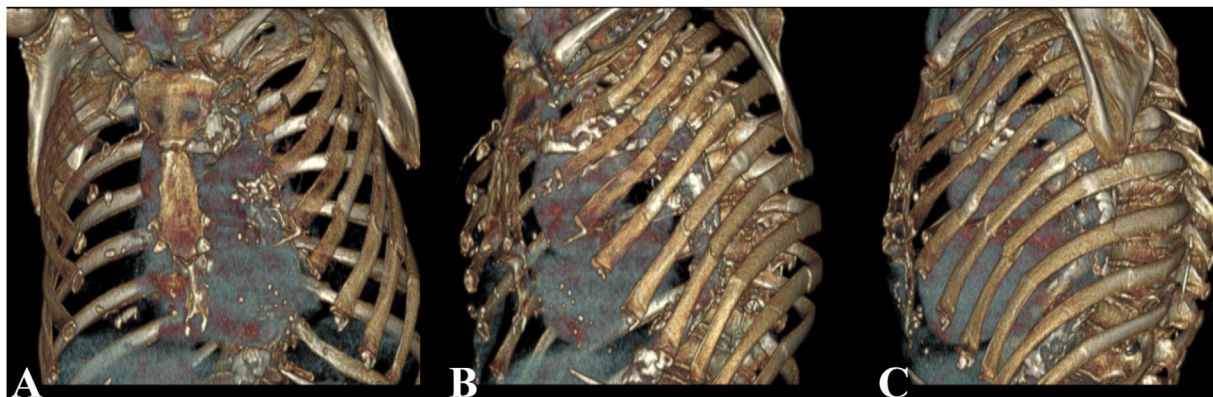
Three-dimensional CT-scan reconstructions showing multiple double or triple rib fractures from the second to the eighth rib, with crushing of the anterolateral chest wall, and single fractures of the ninth and tenth rib.
